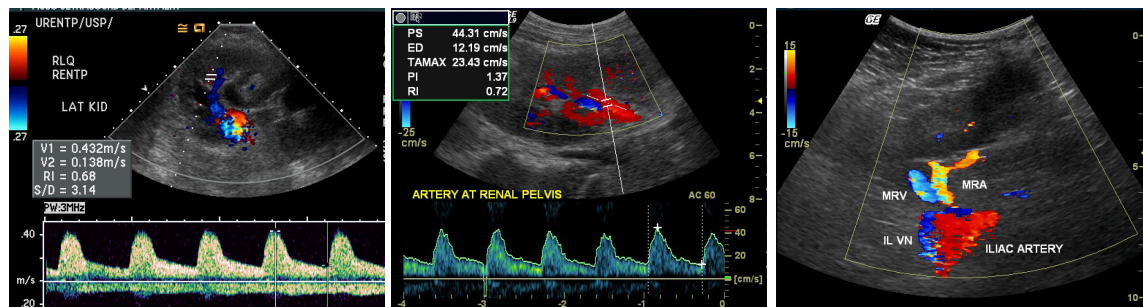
A, B and C: Normal arterial waveform. Image A, a Doppler image through the intrarenal arcuate artery in lateral part of the transplant kidney and image B, through the renal artery at the hilum show normal antegrade flow with sharp systolic upstroke and pan-diastolic antegrade flow. The resistive indices (about 0.7) are within the normal range. Image C, a color Doppler image through the anastomotic site shows normal renal artery and vein anastomosing with the iliac vessels.
